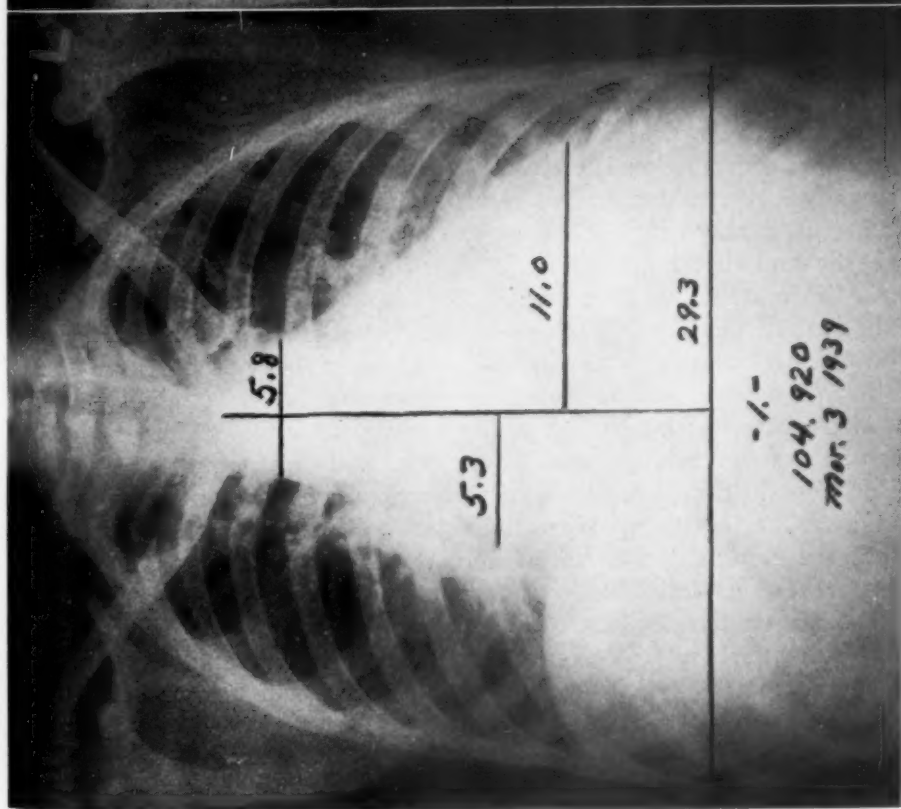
Roentgenograms of patient 2 on admission and 10 days after treatment was begun.
